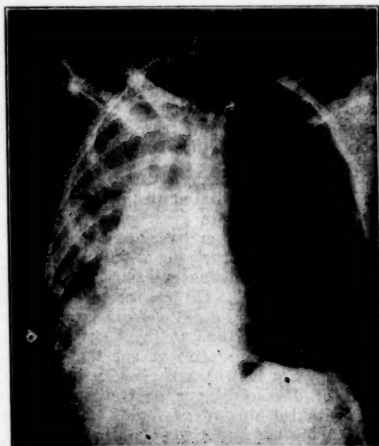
Roentgenogram, Case 1, Sept. 2, 1925. Heart shadow less displaced. Lung clearing in patches. Trachea still slants to right.
